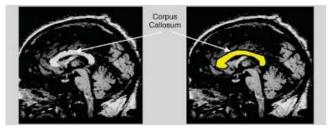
Midsagital MRI brain scan slice showing the corpus callosum (highlighted in the right-hand image)
